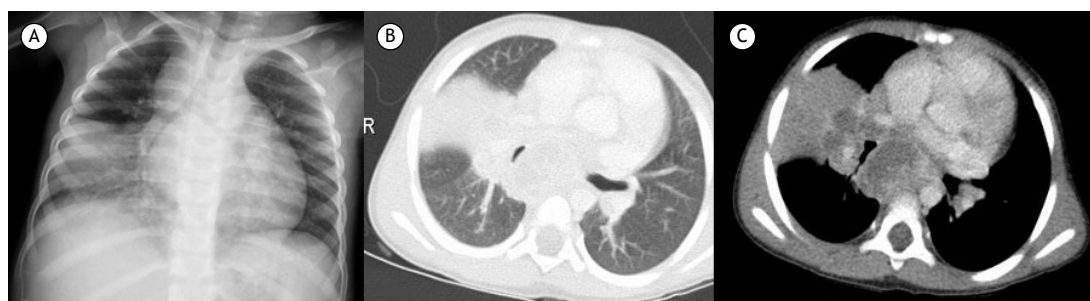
Primary tuberculosis in a child aged four years and nine months. In A, chest X-ray showing opacity in the right middle lower third accompanied by widening of the right paratracheal stripe, consistent with enlarged lymph nodes. In B, chest CT (lung window) showing opacity and extrinsic obstruction of the intermediate bronchus by enlarged lymph nodes, which are indicative of middle lobe syndrome. In C, chest CT (mediastinal window settings) showing enlarged lymph nodes of varying density in the right hilum and posterior mediastinum.
